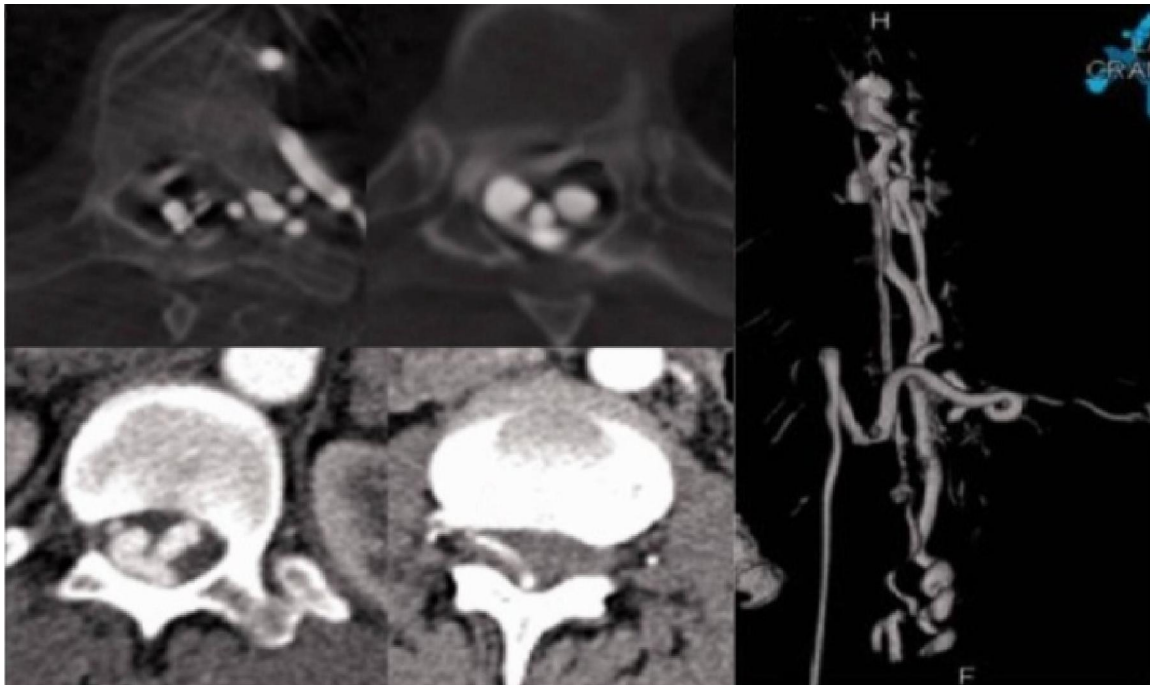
CTA dorsal spine of case (13) shows a vascular-enhancing lesion in the thoracic spinal canal
